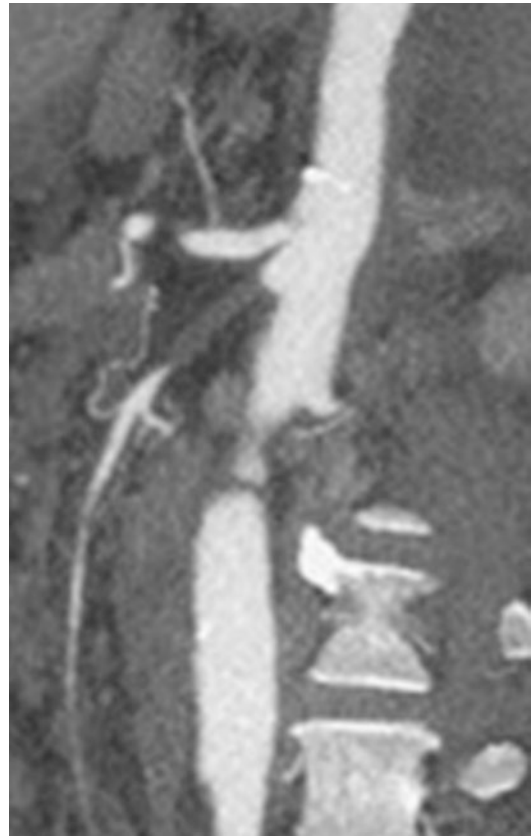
CTA showing SMA thrombosis with reconstitution past the occlusion
